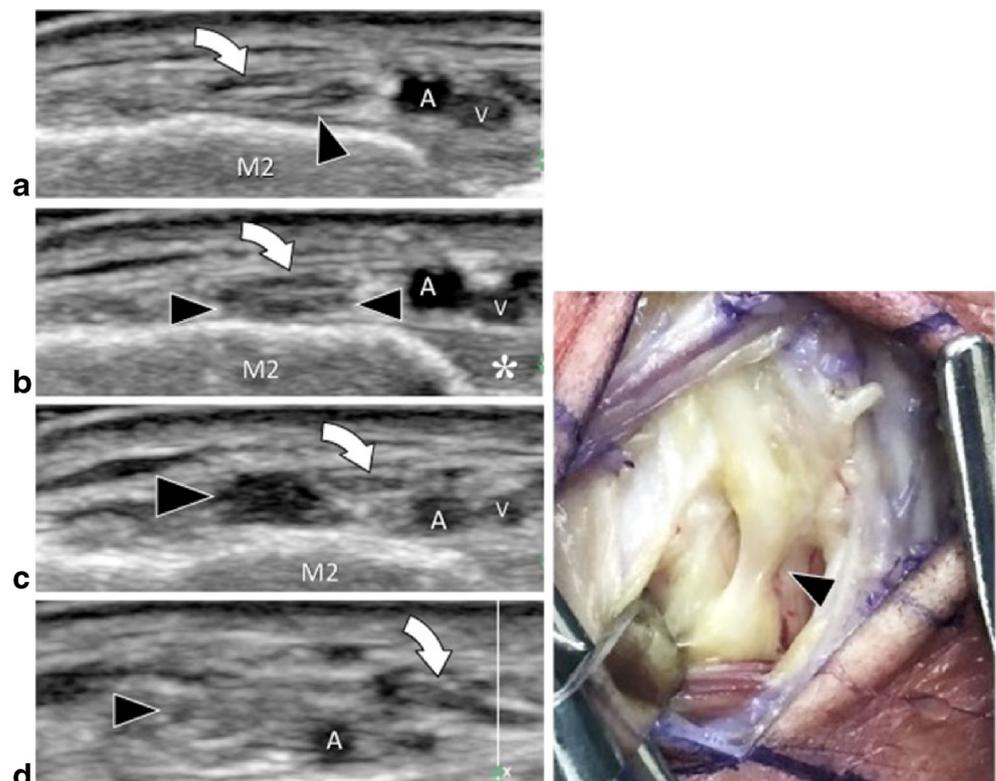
Normal ultrasound anatomy of the MBDFN at the Lisfranc joint. Anatomic dissection of the anterior ankle and foot and axial oblique sonograms obtained from proximal (a) to distal (c). In a–c the MBDFN (black arrowhead) runs medial to the dorsalis pedis artery (A) and veins (V). a The nerve is located between the extensor hallucis brevis tendon (curved arrow) and the dorsal band of the Lisfranc ligament (asterisk). b More distally, the MBDFN runs between the first two metatarsals (M1 and M2). c At the anterior part of the first intermetatarsal space, note the two terminal branches (small arrowheads) of the MBDFN
